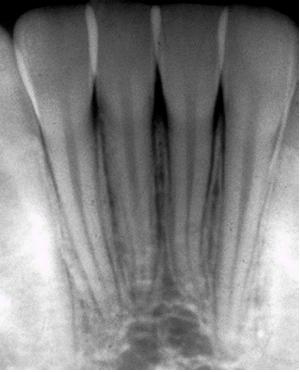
Periapical radiograph of the PDLS and LD surrounding the mandibular incisor roots.
